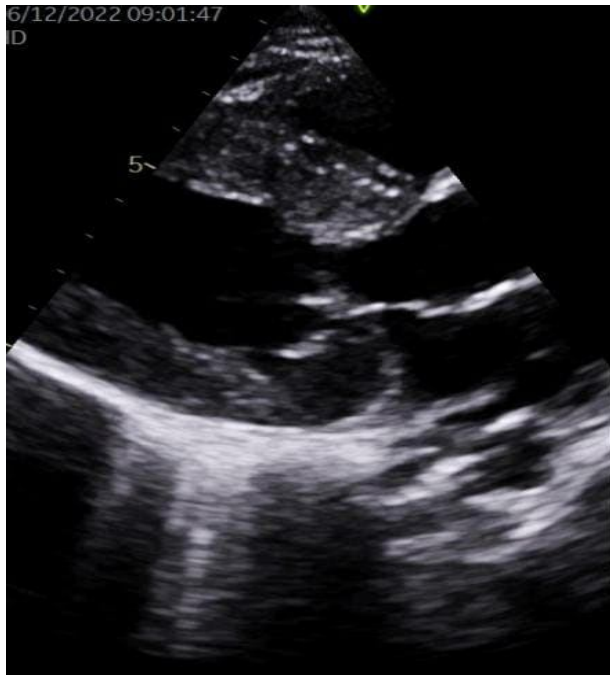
Parasternal long axis view revealed thickened left ventricular walls
